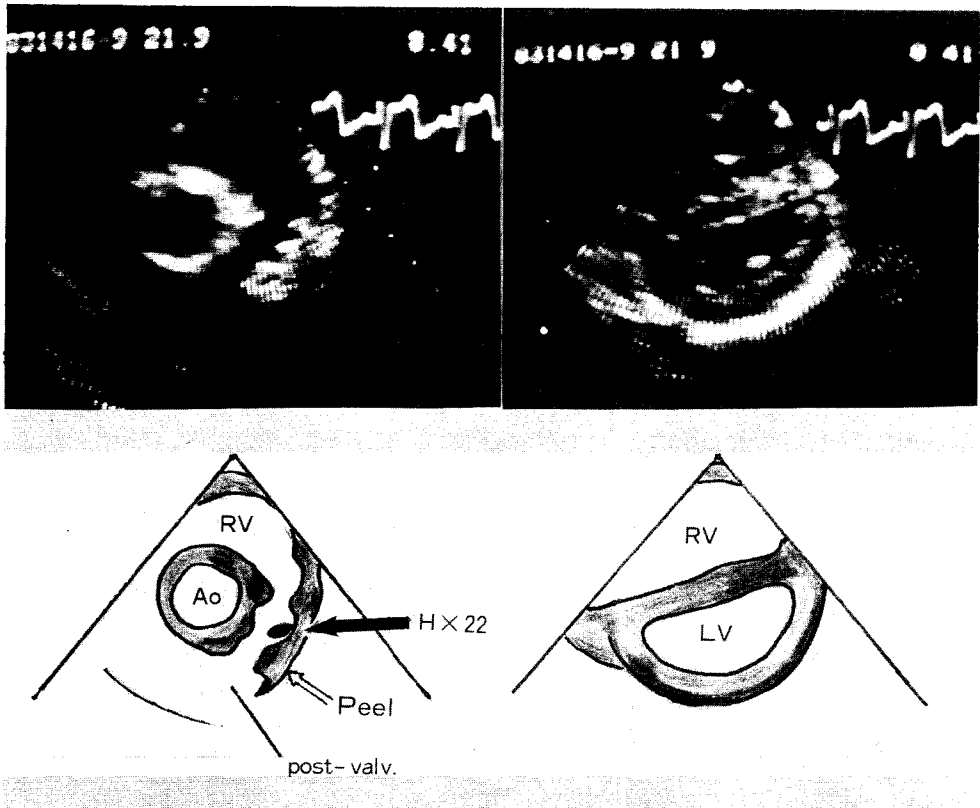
Two-dimensional echocardiogram of case No. 8 demonstrates calcified Hancock valve and thick neointimal peel.
